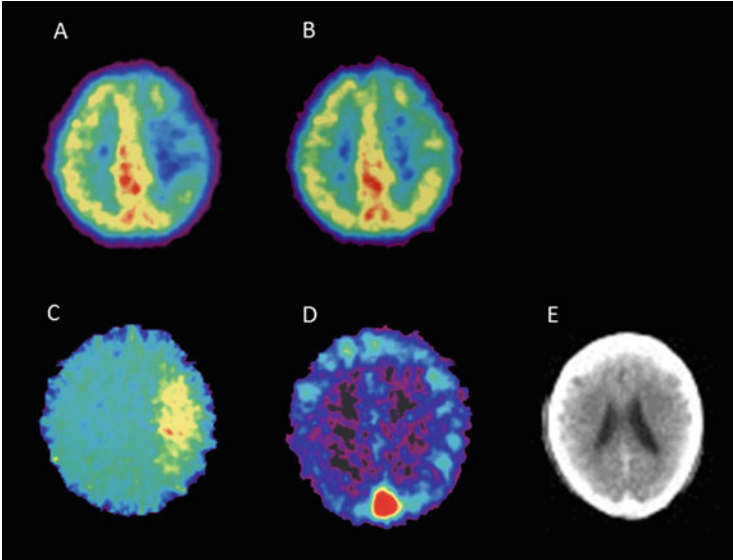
Misery perfusion in a patient with acute left MCA occlusion. PET images of (a) CBF, (b) $CMRO_2$, (c) OEF, and (d) CBV examined on the day of stroke onset. The CBF in the left MCA territory reduced, whereas the $CMRO_2$ in the corresponding area was relatively preserved. The OEF was elevated in the same area, indicating an uncoupled state between perfusion and oxygen metabolism (misery perfusion). A CT image obtained on the same day (e) did not show any morphological changes
